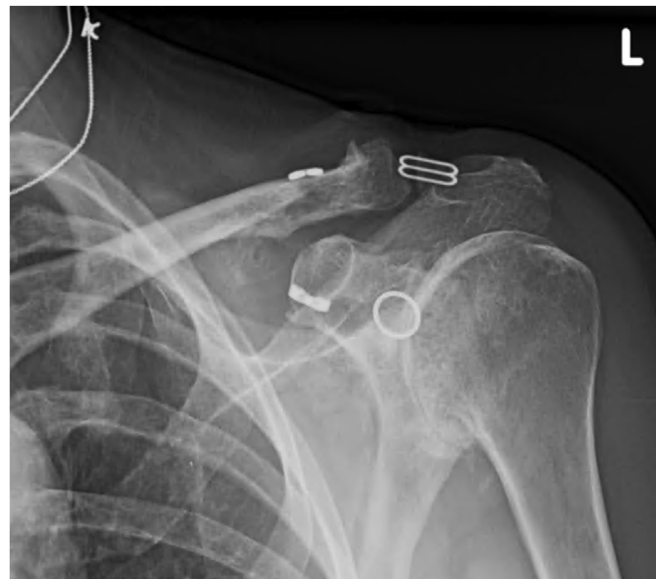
Radiographs at final follow-up demonstrating maintained reduction and complete fracture healing.
